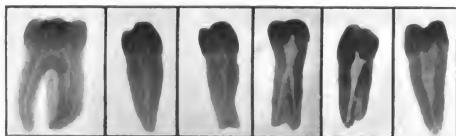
Radiographs showing abnormal branching of root canals.
